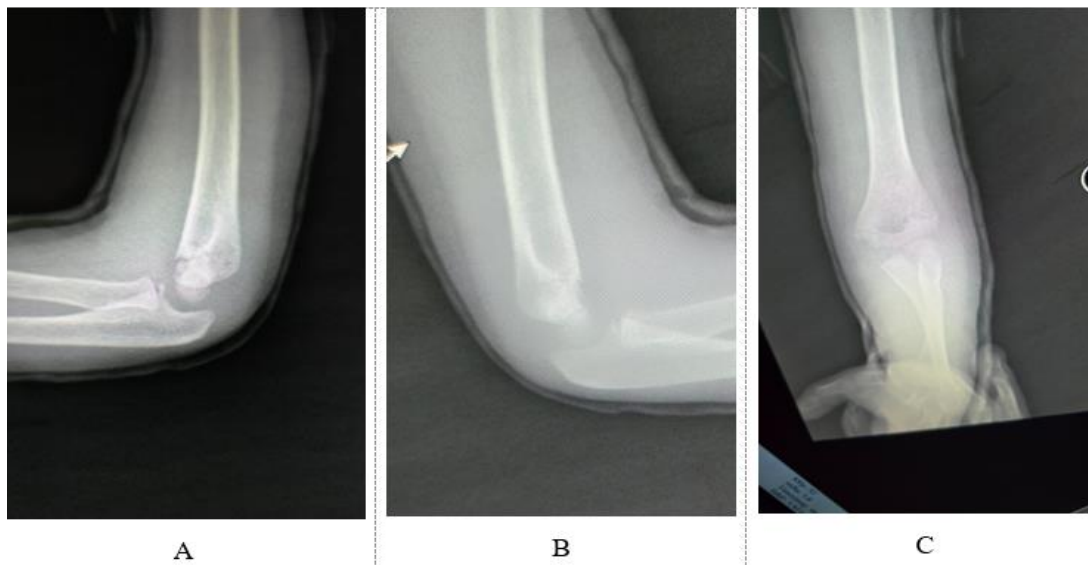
Two-Week Follow-Up Radiographs Demonstrating Continued Stability of Fracture Alignment During Cast Immobilization
